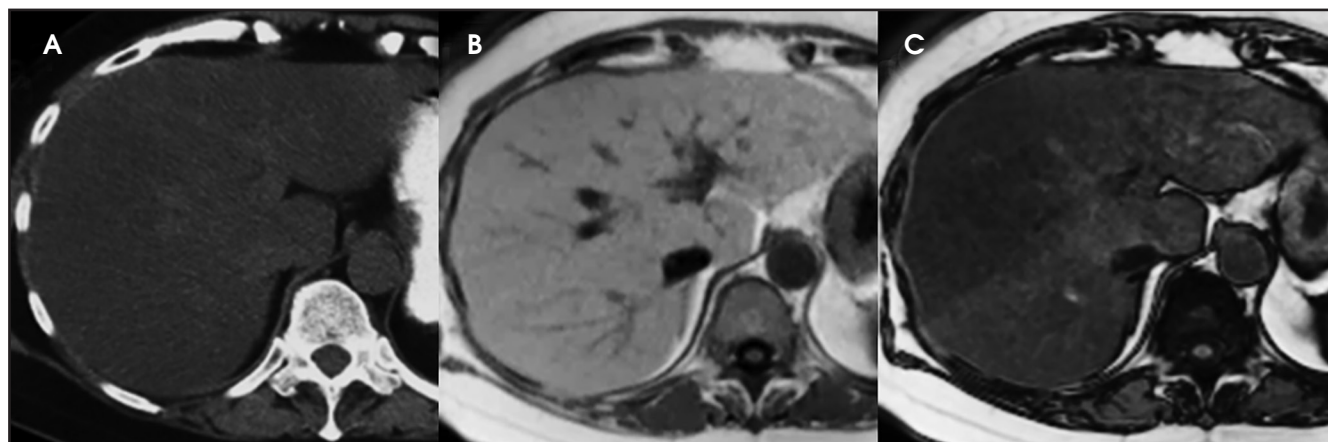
Unenhanced CT (A), axial In-phase (B) and opp-phase (C) images at the same level in a patient with hepatic steatosis. Hepatic steatosis causes diffuse hypo-attenuation of the liver and vessels appear denser and on MRI there is loss of signal in opp-phase. Note the heterogeneity of steatosis.
